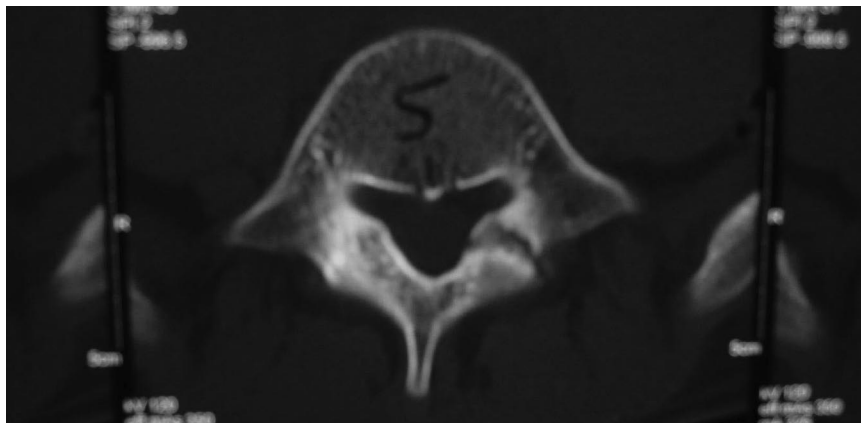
Axial CT of the L5 vertebrae and pars indicating bilateral pars defect. Please note that the defect can be appreciated much more easily on the left; however, there is indeed a defect bilaterally.
